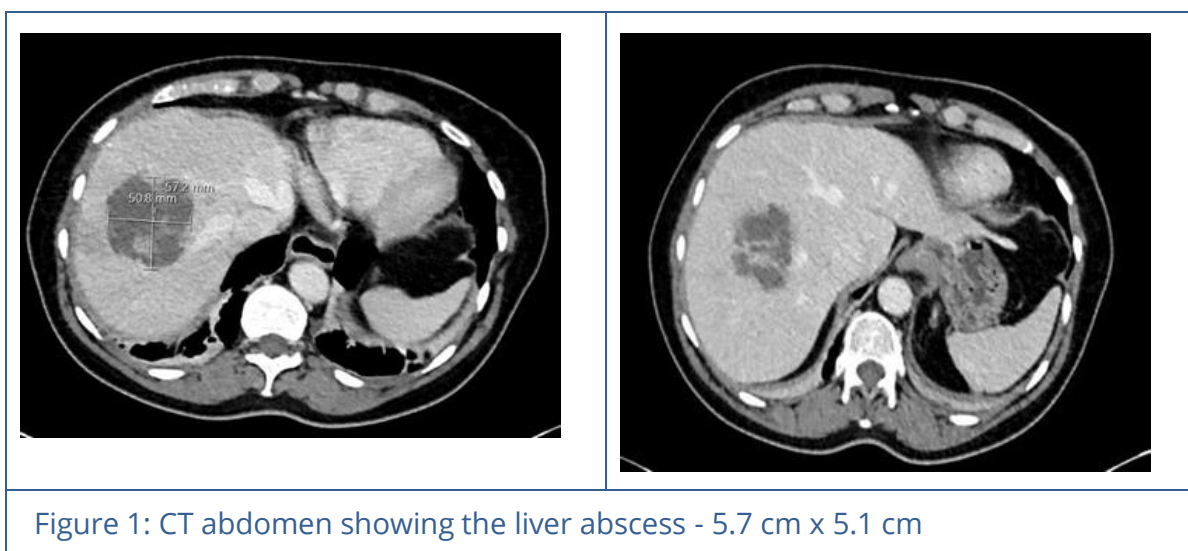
CT abdomen showing the liver abscess - 5.7 cm x 5.1 cm
